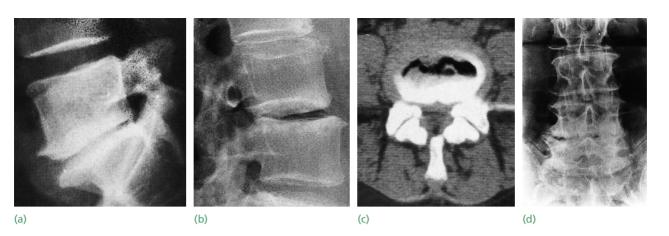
Spondylosis and osteoarthritis Typical X-ray features are (a) narrowing of the intervertebral space and anterior 'osteophytes'. (b) Other features are slight retrolisthesis and a dark (vacant) area in the disc space – the 'vacuum sign' – better demonstrated in the axial CT (c), which also shows the hypertrophic osteoarthritis of the facet joints. (d) In advanced cases there are well-marked signs of osteoarthritis.
